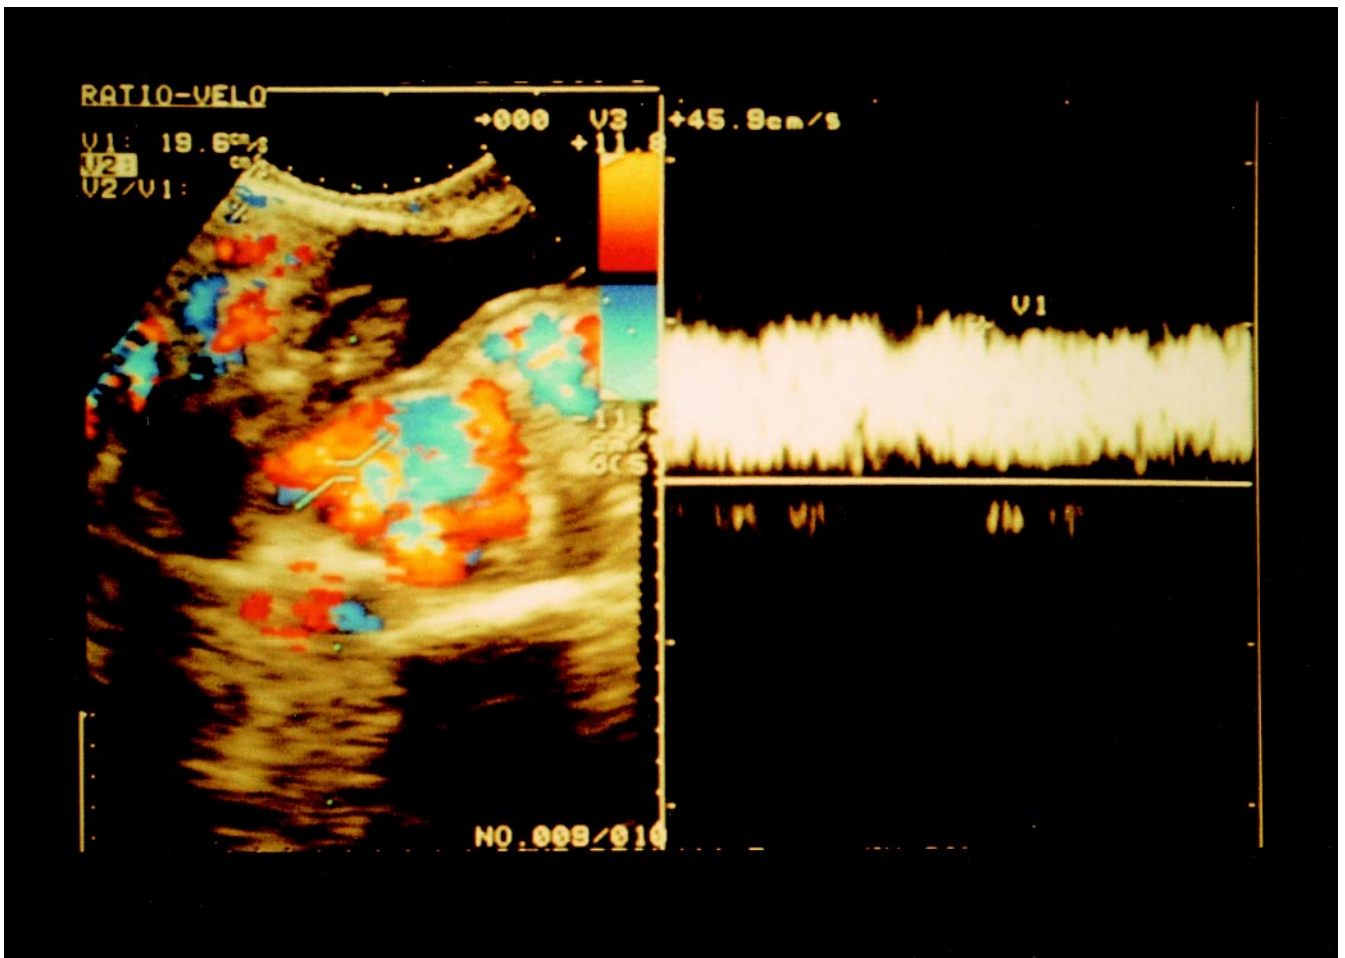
Color flow images of gastric varices were visualized by endoscopic color Doppler ultrasonography, (ECDUS), and fast-Fourier transform analysis indicated a continuous wave
